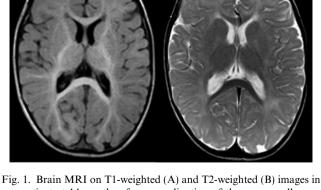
Brain MRI on T1-weighted (A) and T2-weighted (B) images in our patient at 14 months of age: myelination of the corpus callosum, the internal capsules and the subcortical white matter is normal for age.
